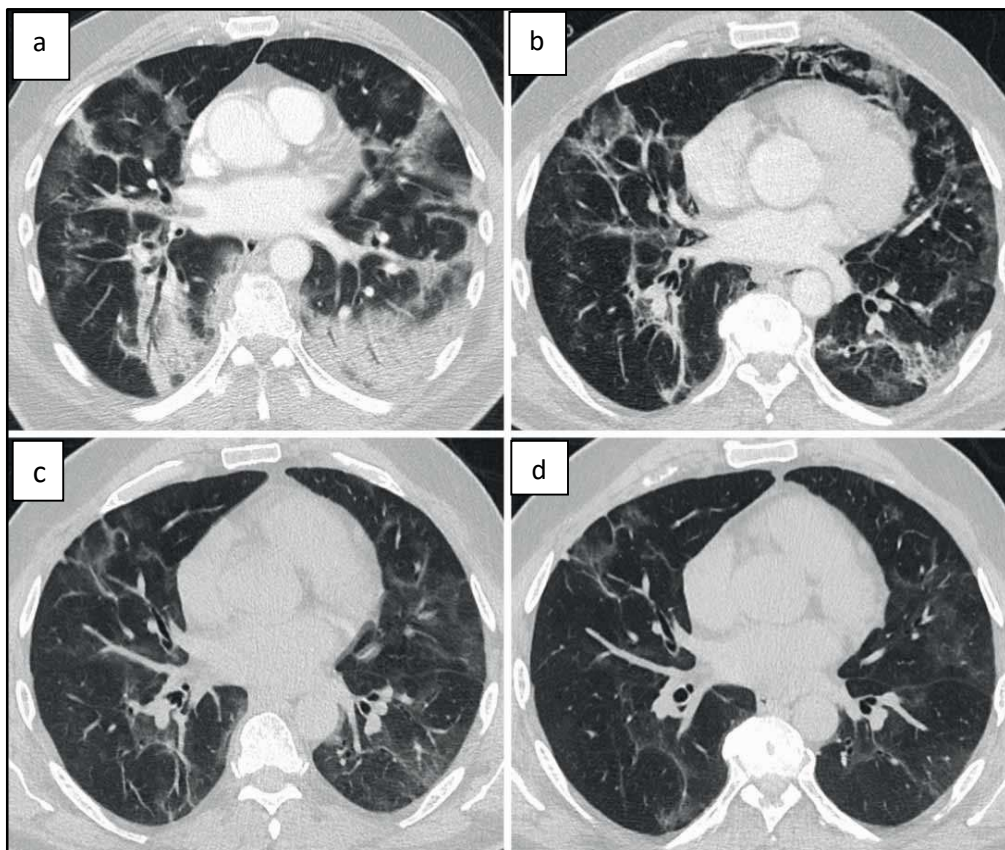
CT thorax of COVID-19 patient– Evidence of a gradual decrease in the CT findings at a) 2 weeks, b) 3 weeks, c) 14 weeks and d) 24 weeks after disease onset ⁸⁰
